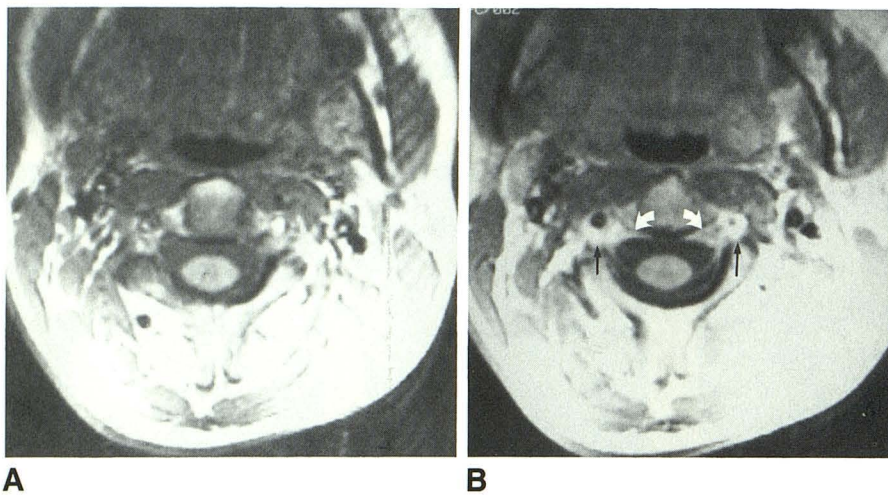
A and B, Enhancement in cervical spinal epidural plexus is shown in pre- (A) and post- (B) Gd-DTPA 800/20/2 MR images. Note increased signal intensity (arrows) in region of epidural plexus, dural sac, and root sleeves.
